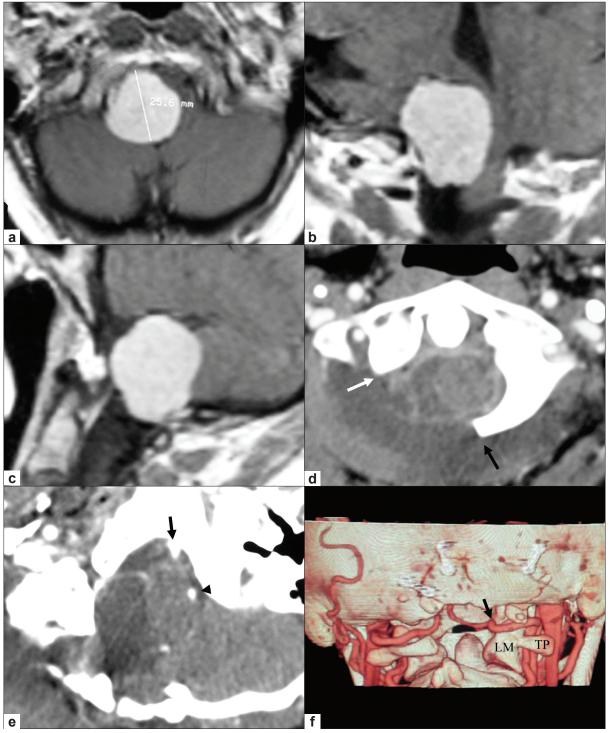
Lateral intradural foramen magnum meningioma. (a-c) Preoperative MRI in axial (a), coronal (b) and sagittal (c) planes. (a) The meningioma inserted on the right side but not across the midline. The tumor displaces the neuraxis antero-laterally and creates a large surgical corridor. (d-f) Postoperative CT-scans, after complete resection of the tumor through a postero-lateral approach. (d) The extension of the CI laminectomy. The white arrow indicates the lateral limit with a CI lateral mass left intact. The access is obtained on the base of insertion as demonstrated by the arrow direction. The laminectomy has been extended over the midline (black arrow) for preventing stretching of the neuraxis on the bone edge during the resection. (e) The size of the craniotomy. Black arrow and arrowhead show respectively the right and left vertebral arteries. (f) shows the vertebral artery V3 and V4 segments courses on a 3D reconstruction. The arrow indicates the V3-V4 junction. LM: CI lateral mass. TP: CI transverse process. Modified with permission. [1]
